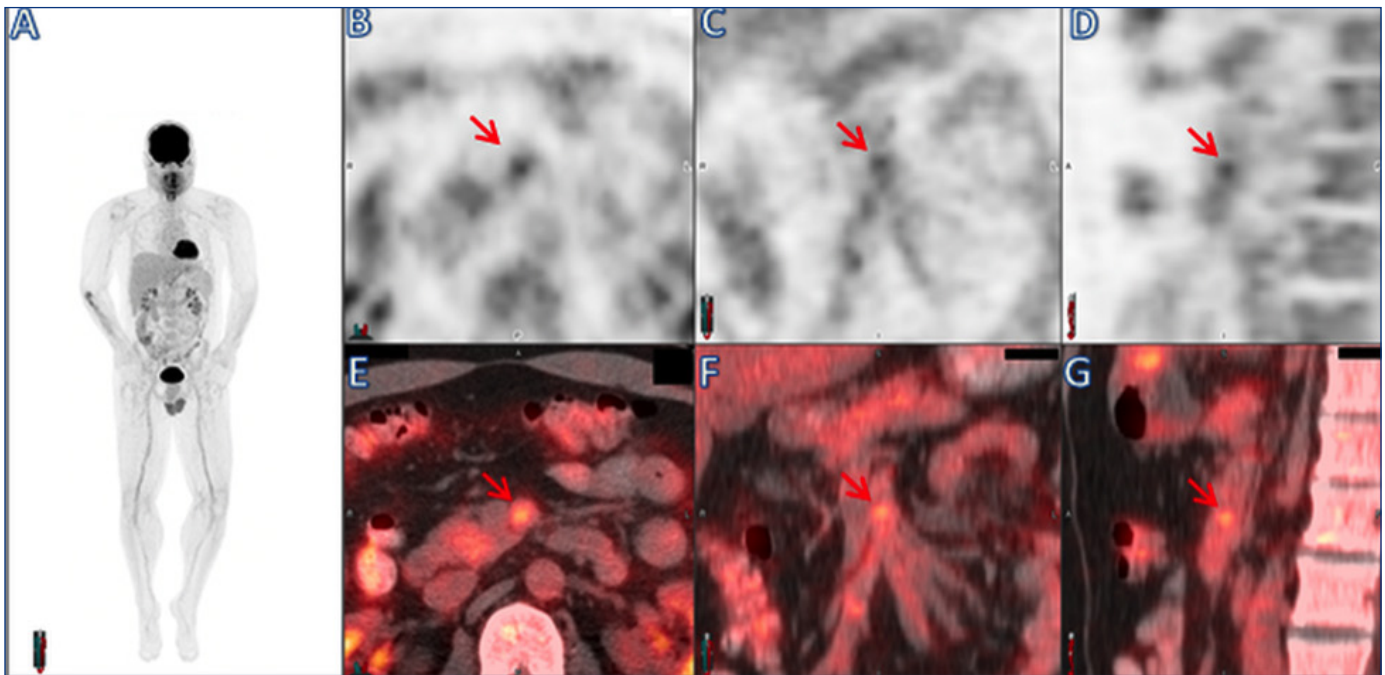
Because of the negative CTA and labeled leukocyte scan, F18-FDG PET/CT was performed to assist in diagnosis, evaluate extent of involvement, and help decide whether to initiate immunosuppressive agents. Whole body MIP F18-FDG PET (A) and axial, coronal, and sagittal PET (B-D, respectively) and fused PET/CT (E-G, respectively) images demonstrate diffuse increased uptake in the mesenteric vasculature, and more focal intense uptake in the SMA (red arrows) in the area of abnormality seen on prior contrast-enhanced CT.
